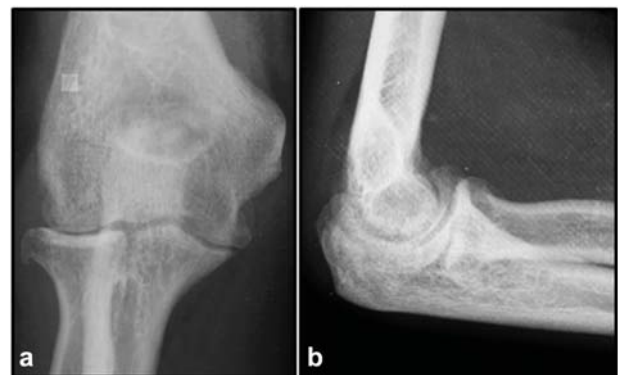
Radiographs after 2 months of the injury showing fracture consolidation with little deformity of the radial head and low degree of osteoarthritis: anteroposterior (a) and lateral (b) views.
